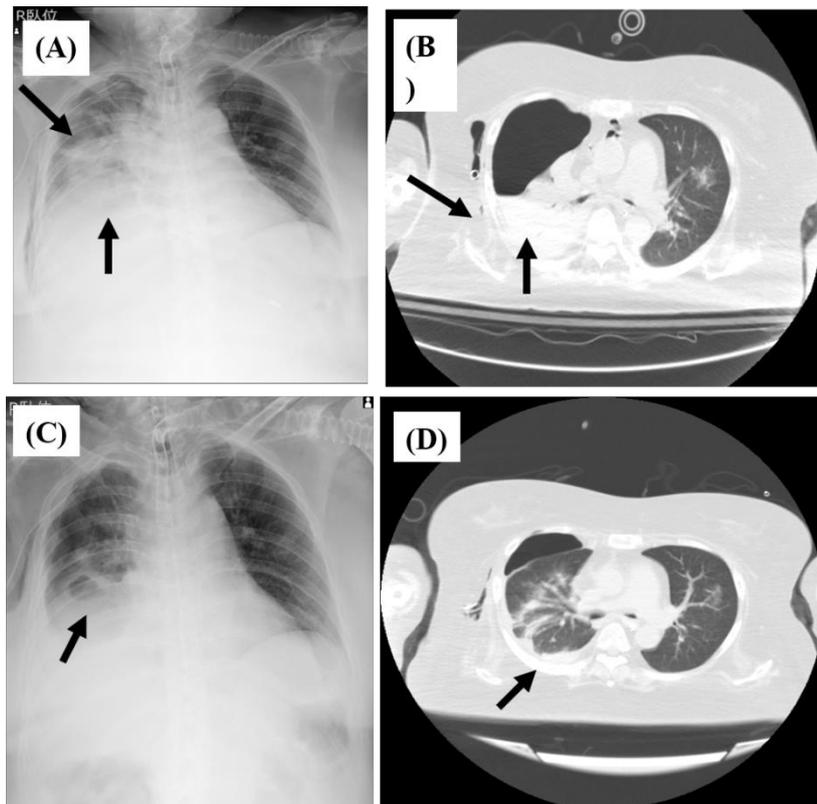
Chest X-ray (A and C) and CT (B and D) of the case 2 patient on day 0. Infiltration shadow is found in her right lower lung field (A and B). On day 10, these shadows are improved both on chest X-ray (C) and on CT (D). Arrows indicate abnormal shadows on chest X-ray and CT, such as infiltration shadows in the lungs.
